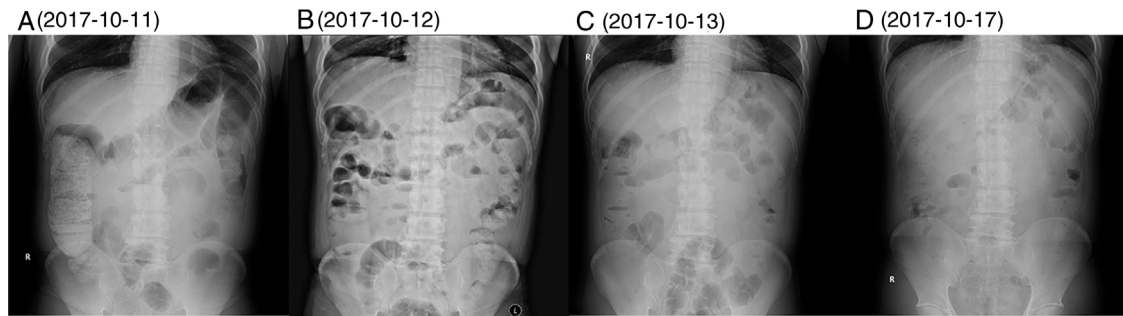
Abdominal X-ray images in this patient. Panel A: Abdominal X-ray performed on October 11, 2017 demonstrated that his bowel was extended with gas accumulation. Panel B: Abdominal X-ray performed on October 12, 2017 demonstrated that his bowel was extended with multiple air-fluid levels. Panel C: Abdominal X-ray performed on October 13, 2017 demonstrated that his bowel was slightly extended without air-fluid level. Panel D: Abdominal X-ray performed on October 17, 2017 demonstrated that his bowel was not extended.
